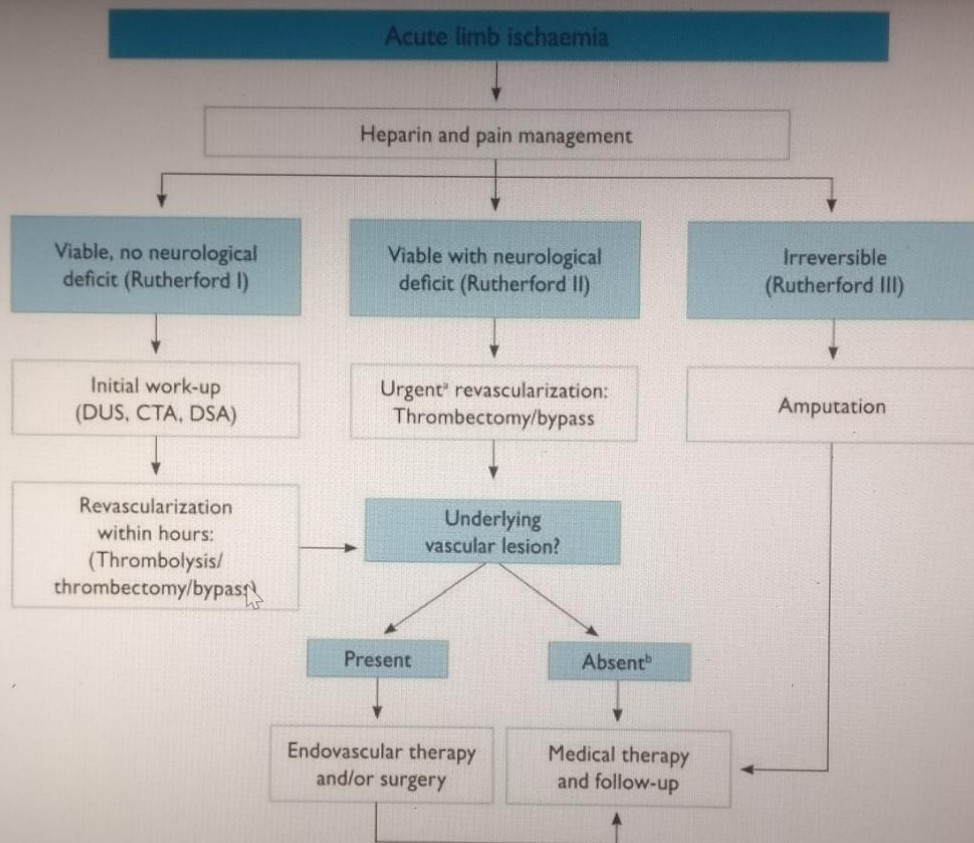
Management of acute limb ischaemia. CTA = computed tomography angiography; DSA = digital subtraction ultrasound; DUS = duplex ultrasound.
